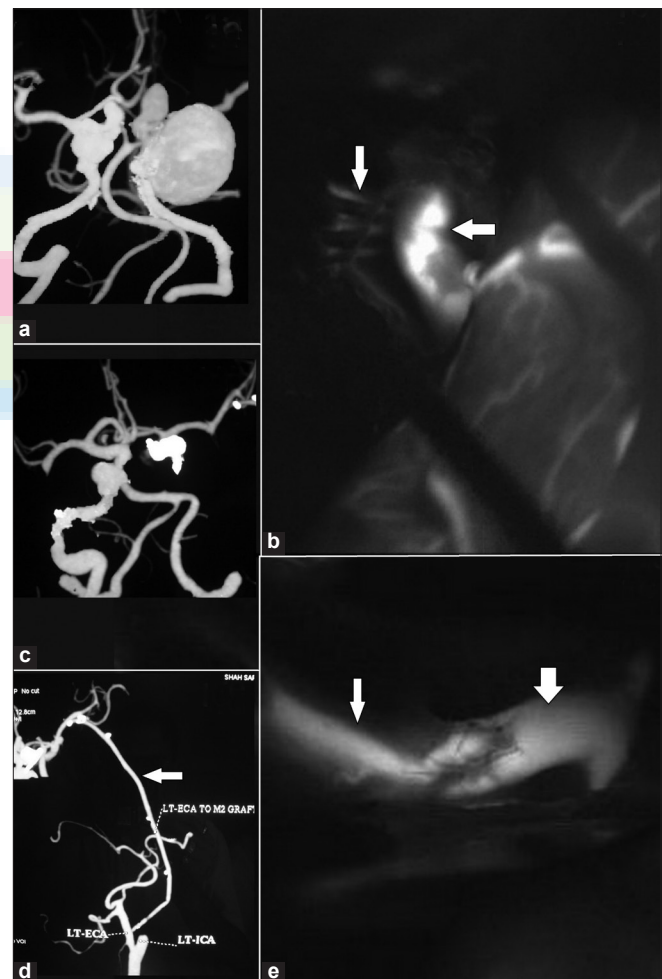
(a) CT angiography showing bilateral cavernous ICA aneurysms and bilateral caroticoophthalmic segment aneurysms. (b) Postclipping ICGVA showing complete obliteration of the fundus of the aneurysm (vertical arrow) and preserved lumen and patency of the internal carotid artery (horizontal arrow). (c) ICGVA showing patent radial artery graft (thin arrow) and the M2 segment of the middle cerebral artery (stout arrow). (d) Postoperative CT angiography confirming the ICGVA findings. (e) Postoperative CT angiography showing patent radial artery graft (arrow)
